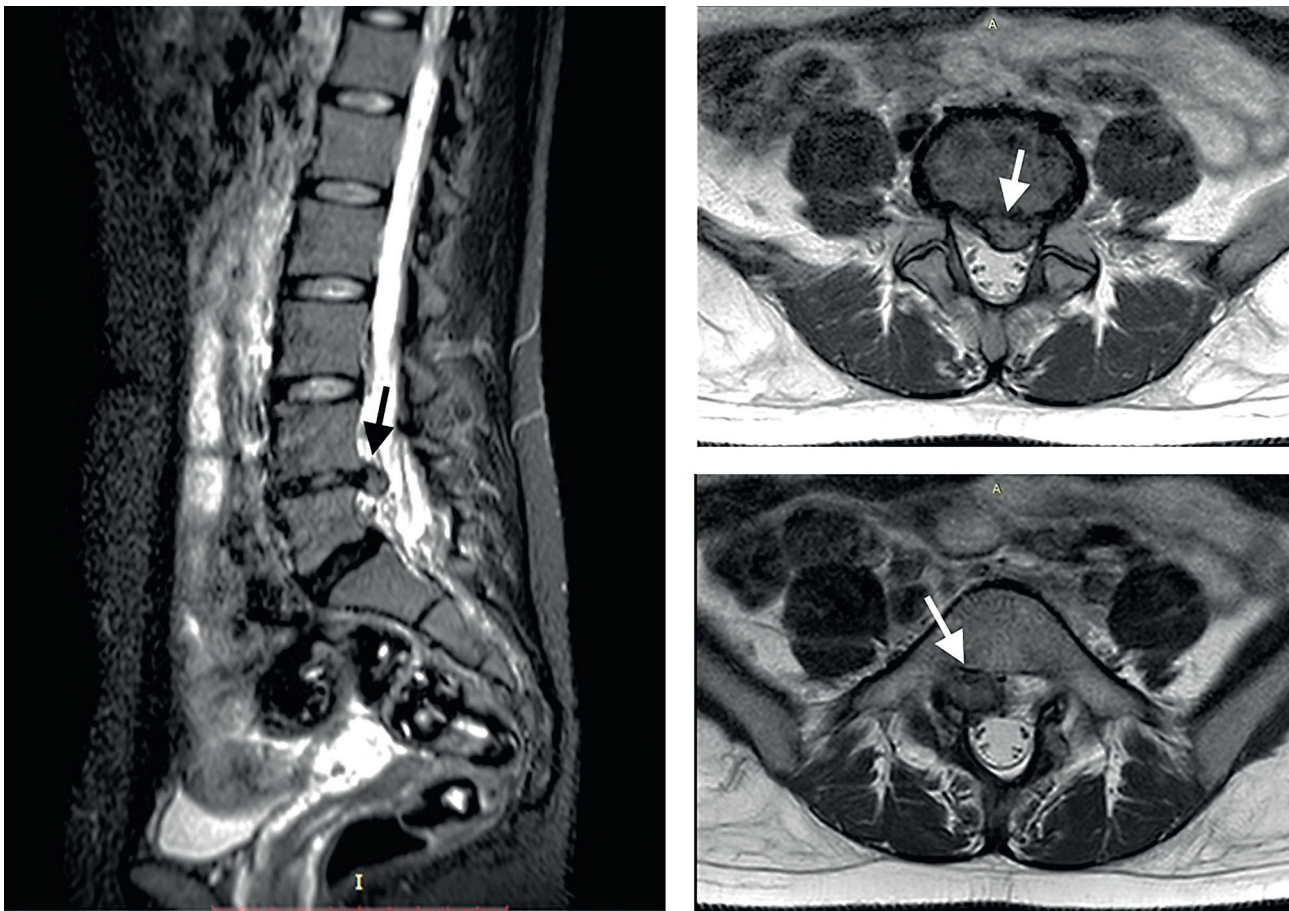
Typical MRI images (T2 weighted) of a 4th lumbar disc, herniated bilaterally (though prevalently to the right).
